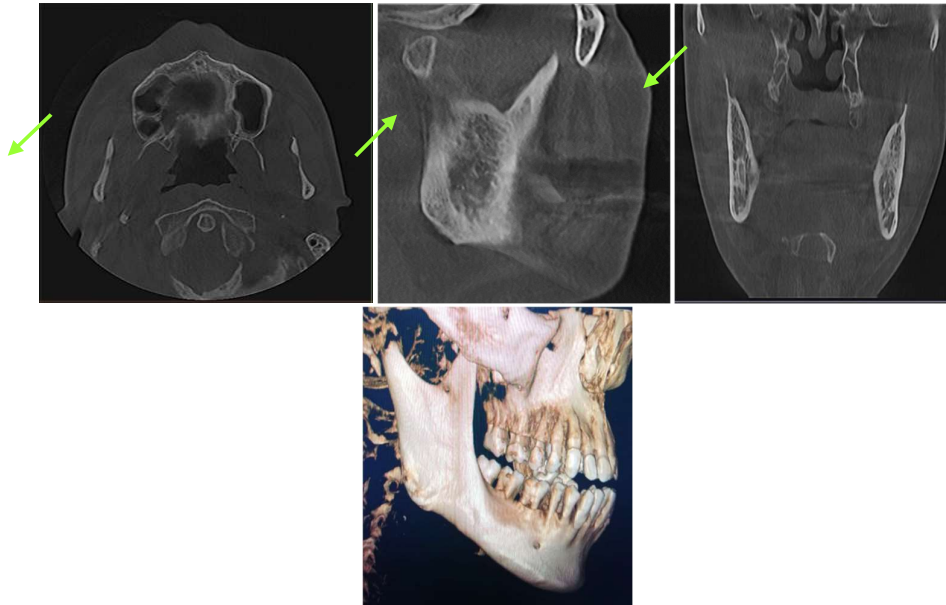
7 Different sections of CBCT
